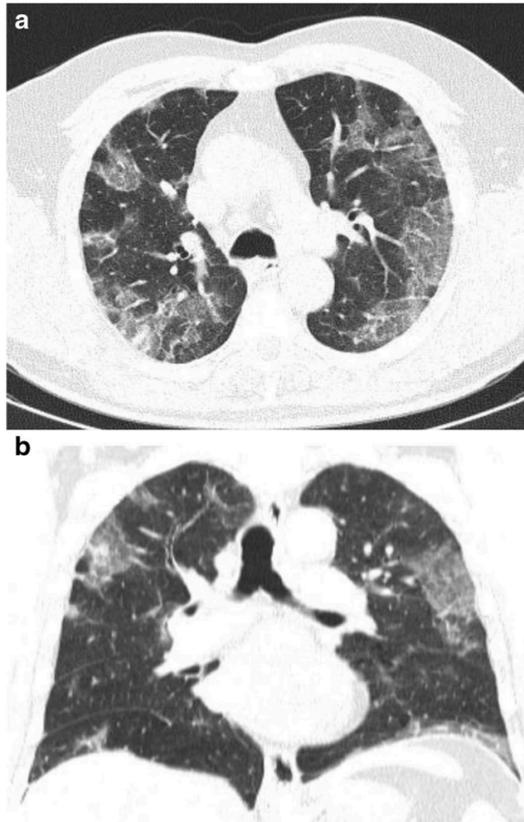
60-year-old man presenting with typical CT findings of COVID-19 confirmed by RT-PCR. a Axial chest CT demonstrates bilateral subpleural ground-glass opacities with superimposed smooth interlobular septal thickening (crazy-paving). b Coronal reformatted CT shows bilateral upper to mid lung gradient, though the lower lobes were involved to a lesser extent
